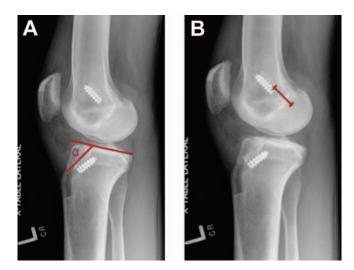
Postoperative radiographic measurements. (A) Tibial α angle and (B) recession distance.
